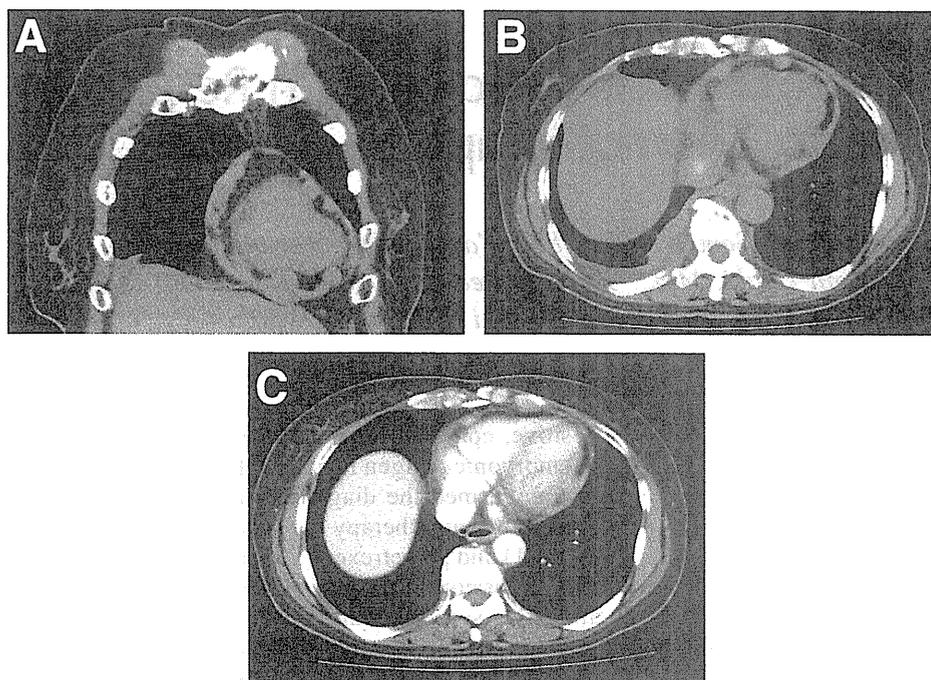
CT scan of the chest at the time of diagnosis showing diffuse thickening of the pericardium; (A) sagittal and (B) horizontal views. After administration of chemotherapy consisting of carboplatin and pemetrexed, (C) regression of the pericardial thickening was exhibited.
